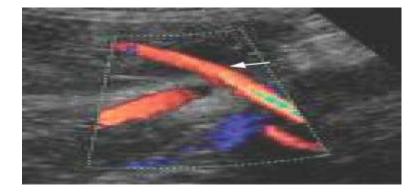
Colour Doppler ultrasound scan showing uterine artery (arrow).
